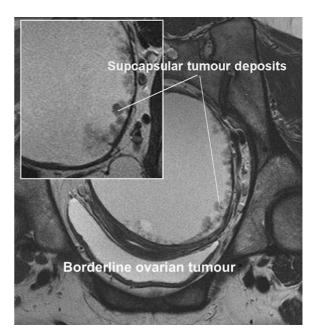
Oblique 3T MR image of a borderline ovarian malignancy showing details of subcapsular tumour deposits.
